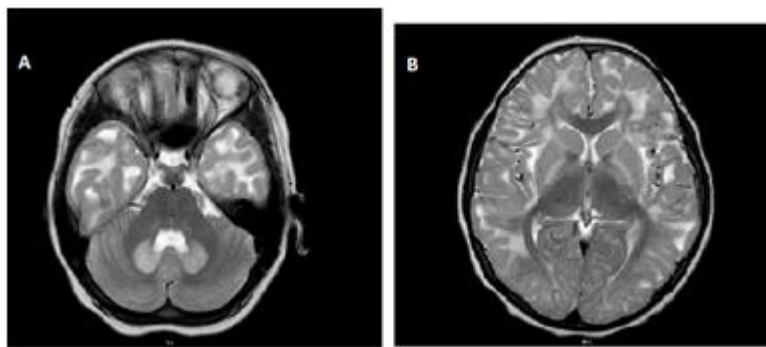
(A) Axial T2-weighted MR images of the brain of patient 1 showing high signal intensity of the dentate nuclei sparing the brainstem and cerebellar white matter, a finding that is characteristic of L2-OH-glutaric aciduria. (B) Bilateral confluent areas of high signal intensity in the subcortical white matter and subcortical U-fibers sparing the deep white matter of the periventricular region, corpus callosum and internal capsule.
